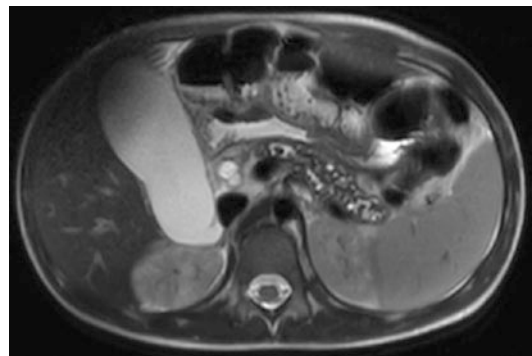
MRCP findings in chronic pancreatitis. Magnetic resonance imaging (MRI/ MRCP) in a 9-year-old male with CP showing diffuse parenchymal atrophy, duct dilatations in the head and neck of the pancreas with several dilated side branches elsewhere. There are several foci of low signal intensity consistent with extensive pancreatic calcifications, including intraductal stones. (Image is courtesy of Dr. Andrew Trout, Cincinnati Children's Hospital, Cincinnati, Ohio, USA)
